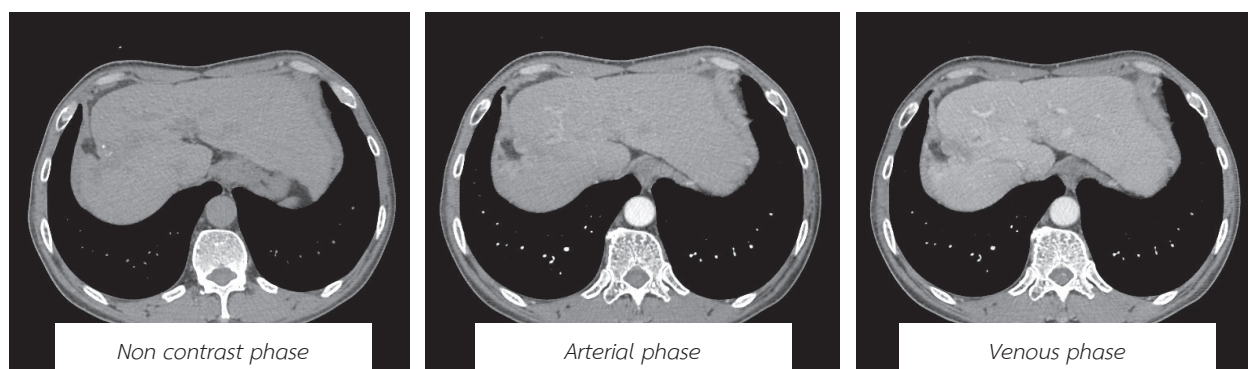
Tripple-phase abdomen CT showed liver cirrhosis with multiple varices and collateral vessels. Liver parenchyma defect at hepatic segment V and VIII with a rather wedge-shaped hypodense lesion involving hepatic segment IV/V and subcapsular retraction which apex point to liver hilum are noted. Multiple small arterial enhancing/delayed washout nodule along the liver parenchyma defect and subcapsular retraction size up to 2 cm. These finding could be confluent hepatic fibrosis or post-surgical change with small hepatocellular carcinoma.
